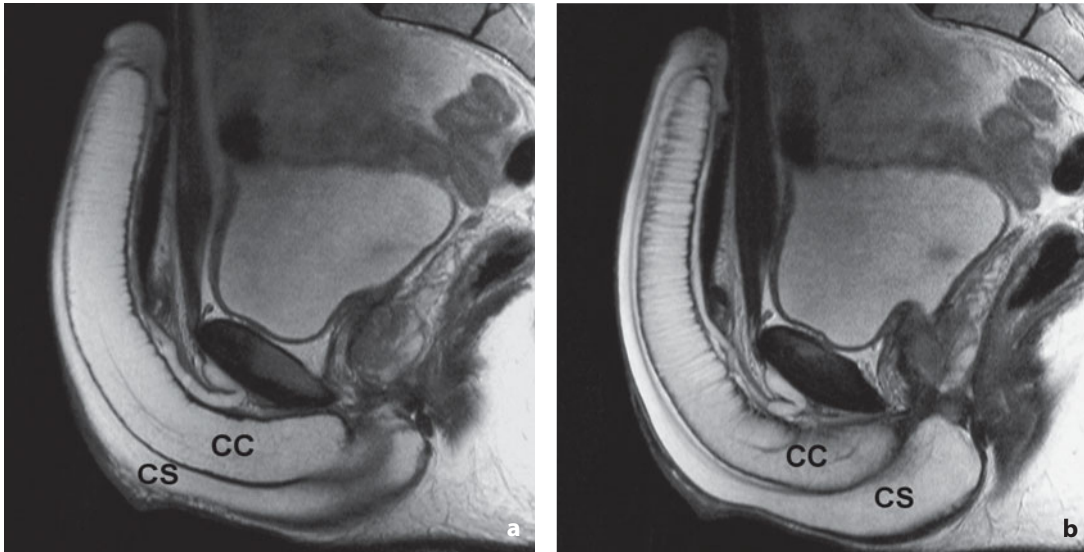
Magnetic resonance. Penis. T2-weighted sagittal images acquired with pharmacologic stimulation. CC, corpora cavernosa; CS, corpus spongiosum
